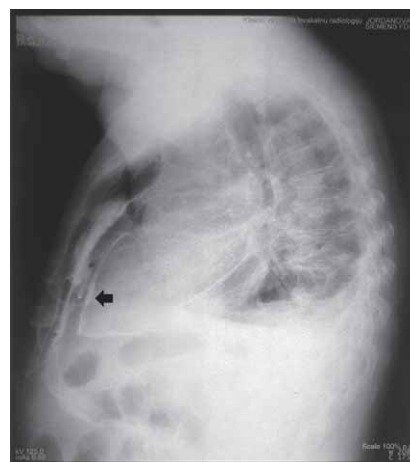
Chest X-ray (lateral) showing contrast extralumination into pericardium (black arrow).
